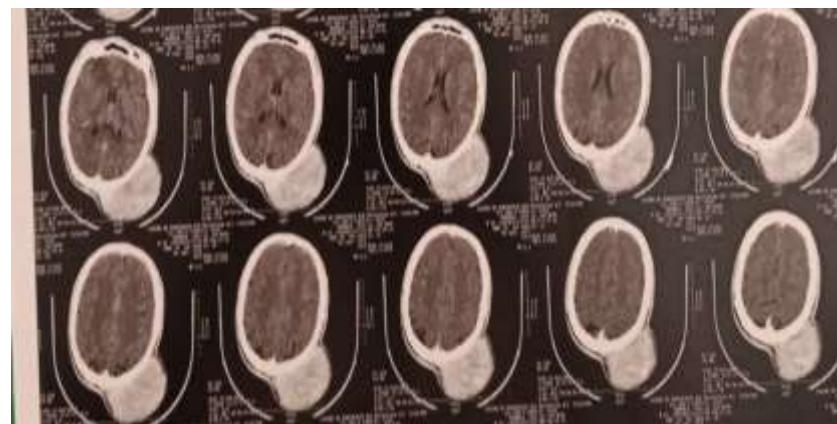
CT image showing the subcutaneous occipital lesion
